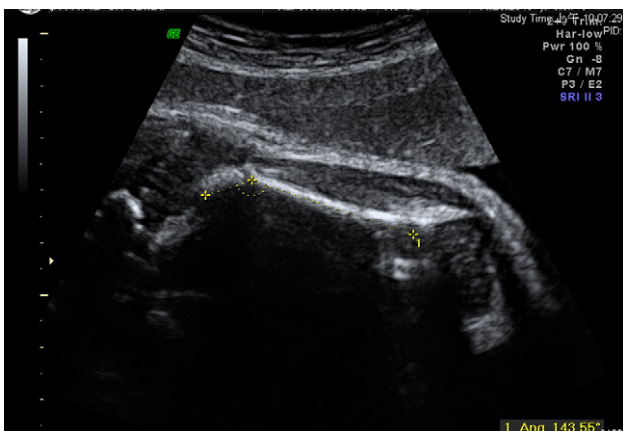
Two-dimensional ultrasound at 32 weeks' gestation reported an over-rounded metaphyseal-epiphyseal interface at the femur ends with wide angle 143.55° while connecting to diaphysis. This also called "collar hoop" sign.
